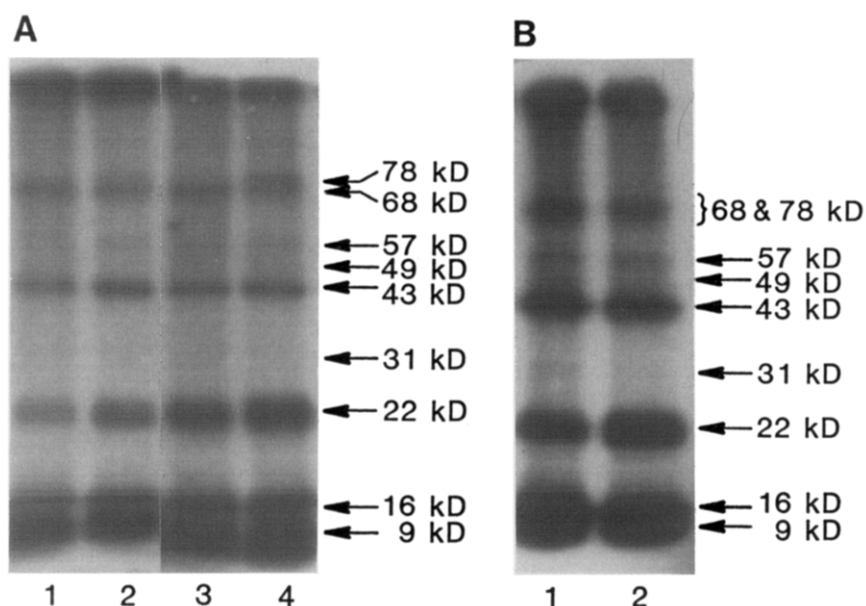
Effect of noninsulin-dependent diabetes and alamethicin on membrane phosphorylation. Sarcolemma was prepared according to the method of Pitts [18]. The isolated membrane was phosphorylated as described in Fig. 2 except 10 mM NaF and 1 mg alamethicin/mg membrane protein was also included in the incubation medium. The solubilized proteins were subjected to polyacrylamide gel electrophoresis, followed by autoradiography. Figure (A) shows an autoradiogram of nondiabetic (lanes 1 and 3) and diabetic (lanes 2 and 4) sarcolemmal proteins phosphorylated in the presence (lanes 3 and 4) and absence (lanes 1 and 2) of 150 units cAMP-dependent protein kinase catalytic subunit. Lanes 3 and 4 of figure (A) represent the same run as figure (B) except the length of time the X-ray film was exposed to the dried gel was prolonged (20 h in (A) and 48 h in (B)). The longer exposure was necessary to clarify differences (bands at 31 kDa and 49 kDa) between the nondiabetic (lane 1) and diabetic (lane 2) samples.
